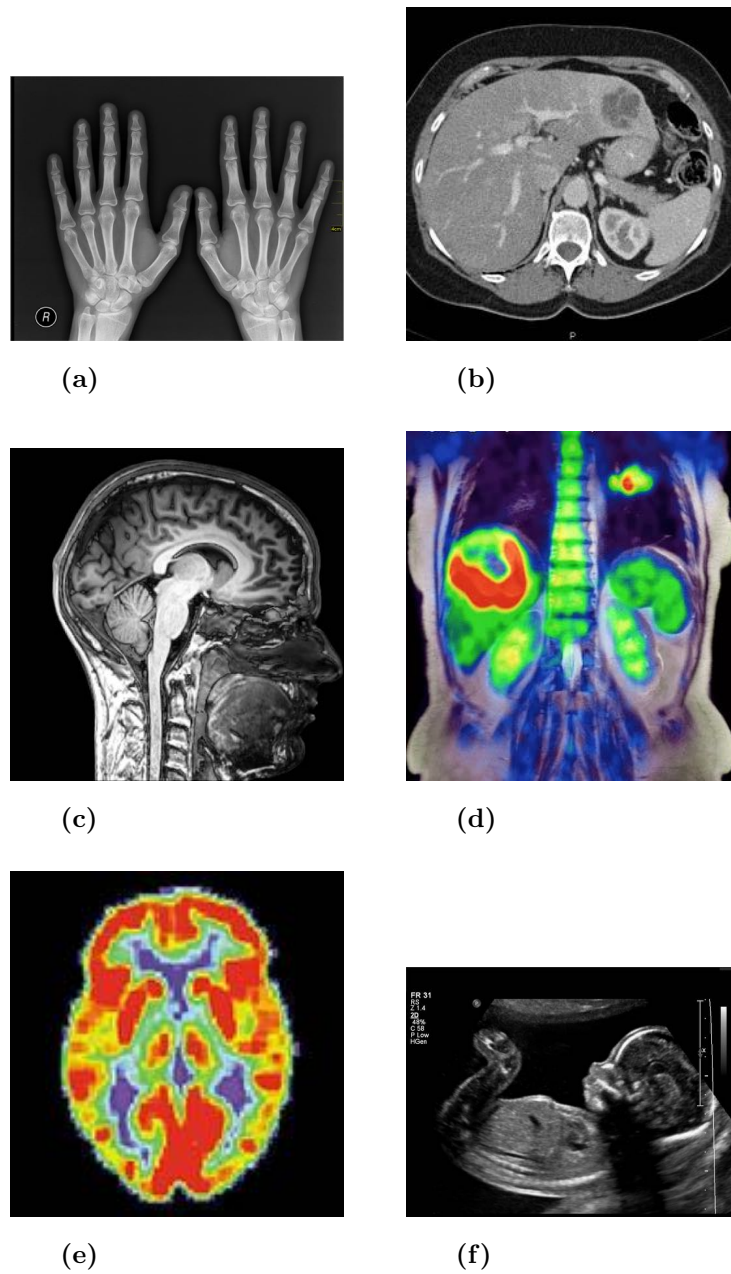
Different Modalities used in Medical Imaging. Image (a) is the X-Ray of hands, (b) is a CT of abdomen showing viscera. Image (c) is an MRI of the head and neck. Images (d) and (e) are the PET scan of abdomen and SPECT of brain respectively. Image (f) is the ultrasound of a human baby in mother's womb. ([Radiopaedia.org](http://Radiopaedia.org) 2014)
